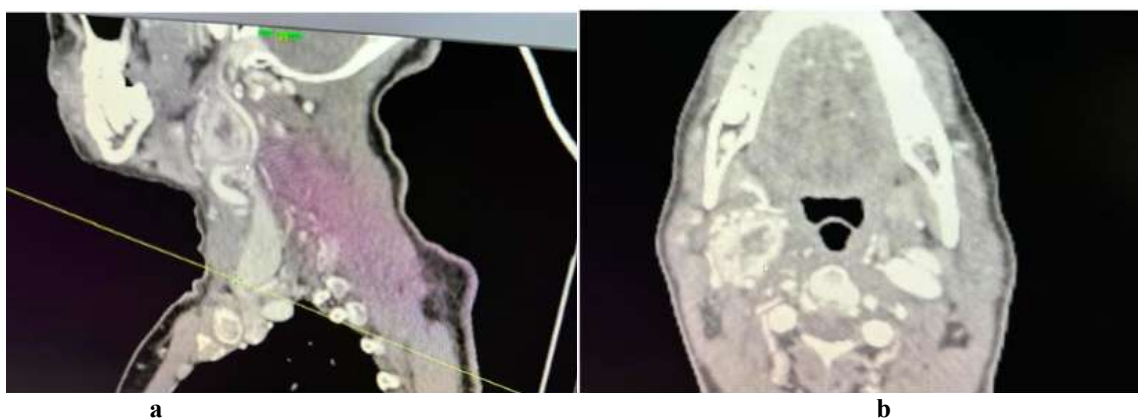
Sagittal (a) and axial (b) cross-sections from a post radiotherapy CT angiography of the supra-aortic trunks showing a reduction in the size of the right carotid paraganglioma decreasing from 39 x 29 x 43 mm to 34x23x44 mm in diameter
